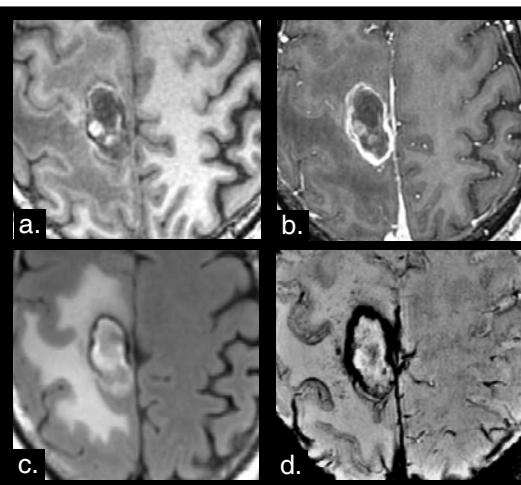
Full FOV SWI for a recurrent glioma patient post-therapy. In (a-c) corresponding 3T anatomical scans: (a) pre-Gd and (b) post-Gd T1 SPGR, (c) T2 FLAIR. In (d) 7T SWI.
